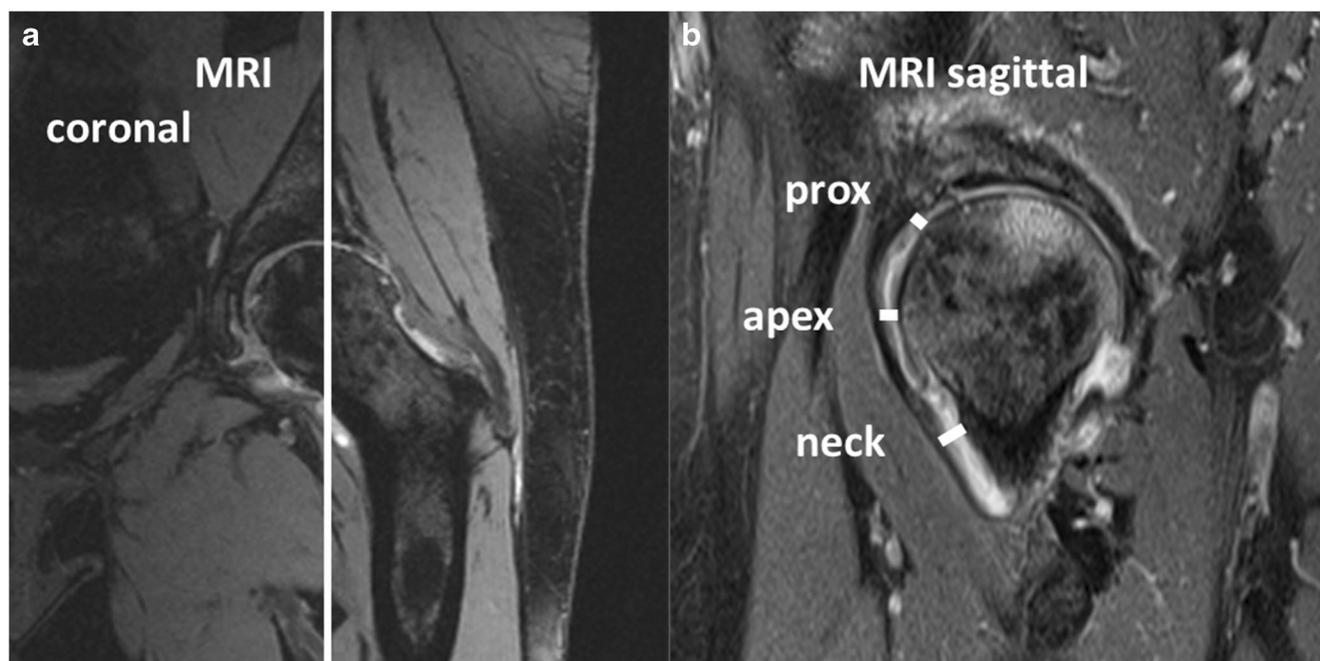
a Coronal MRI view with line for sagittal cross section. b BCD measurement of effusion-synovitis on MRI at proximal, apex, and neck locations
